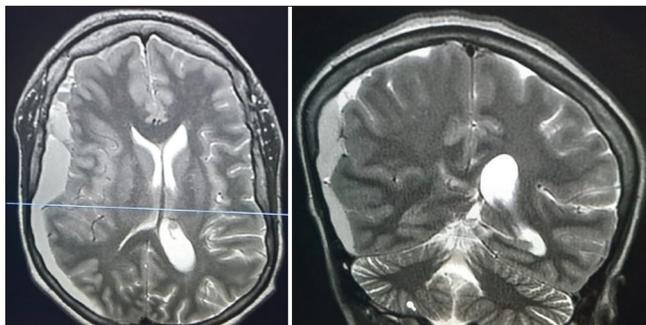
Magnetic resonance imaging showing a right frontoparietal acute subdural hematoma.
